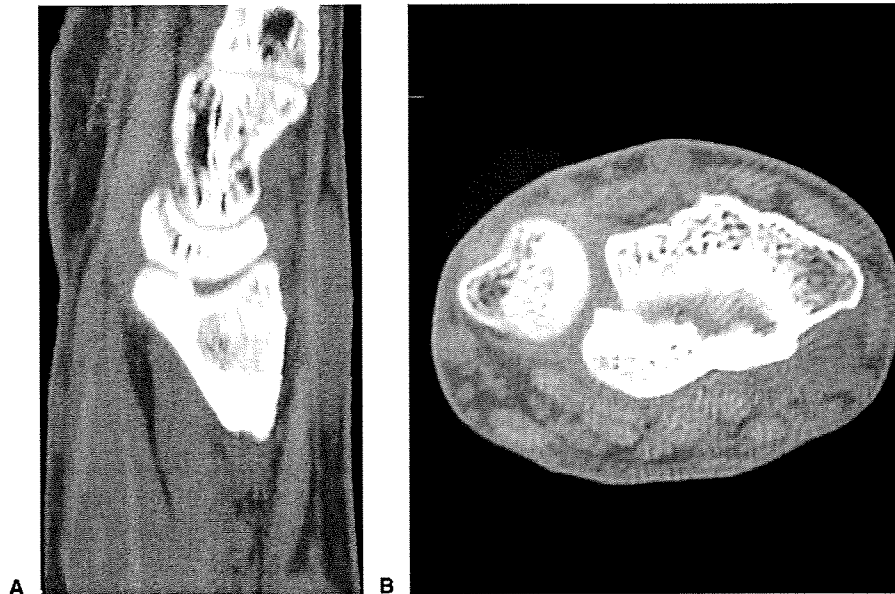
Computed tomography showed A a 3-mm step-off of the articular surface of the distal radius and B distal and ulnar migration of the volar fragment.
